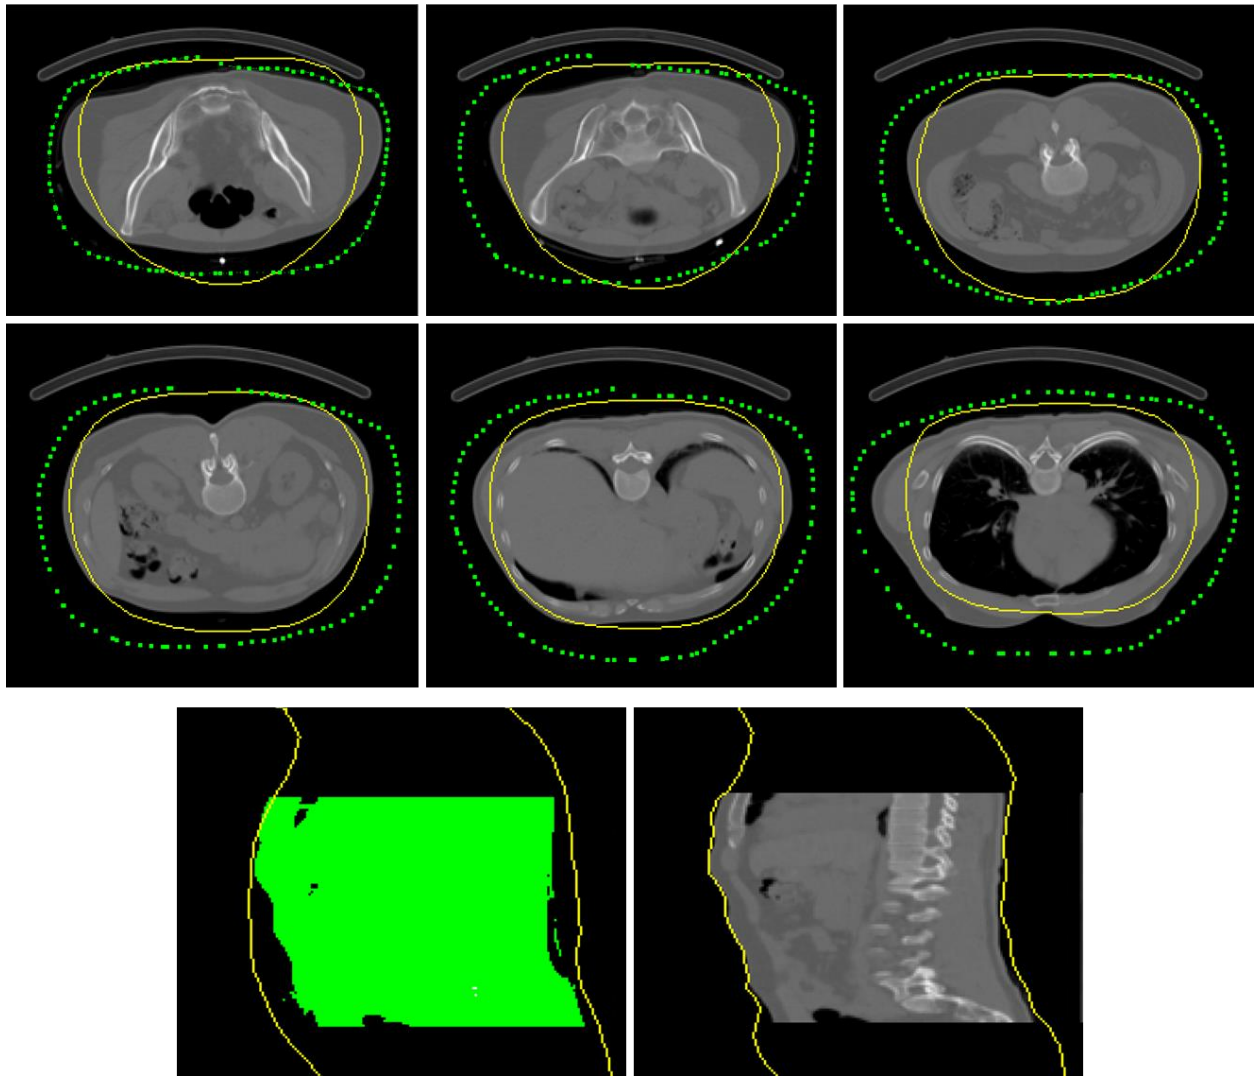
Example of fitting the body contour to the patient. The ROI contours are defined approximately every 20 slices in the axial view (top). The surface mask is created using a threshold range of CT intensities and interpolated in the longitudinal direction (lower left). The partial NURBS surface is fit to the mask (lower right).
